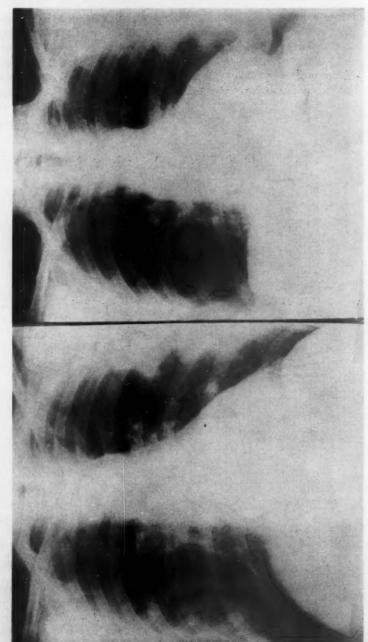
Preoperative and postoperative chest x-rays from a patient with aortic stenosis. The stenosis had recurred when the second film was taken.
